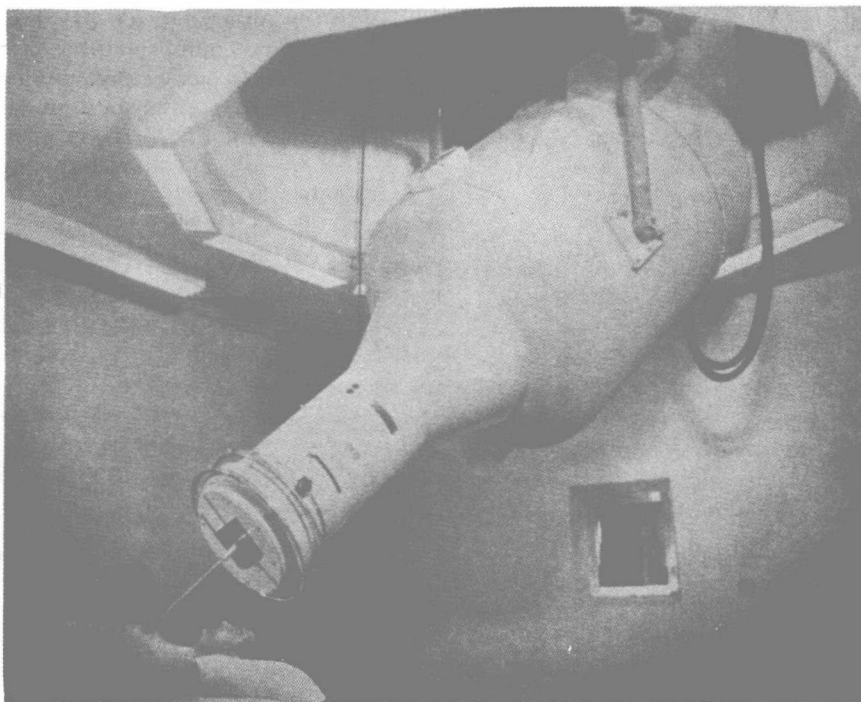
G. E. two million volt x-ray unit. The unit consists principally of a low-frequency resonance transformer with a co-axially mounted scaled-off multisection x-ray tube within, both contained in a steel tank and insulated with compressed gas. The x-rays are generated at a target mounted in the end of the extension chamber projecting from one end of the tank. (Courtesy General Electric Company and Hospital for Joint Diseases, N. Y. C.)
